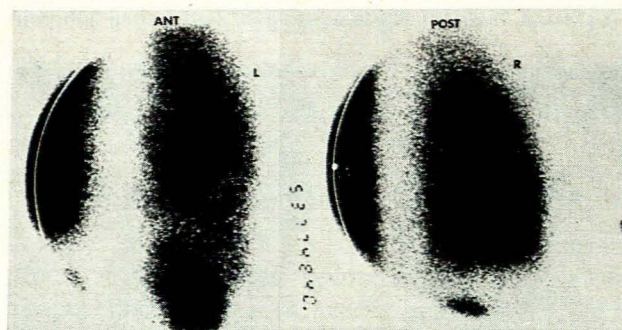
Perfusion lung scintigrams showing left lung and kidney, and right lung and upper pole of right kidney. No 'cold' areas can be seen in the right lower lobe.
